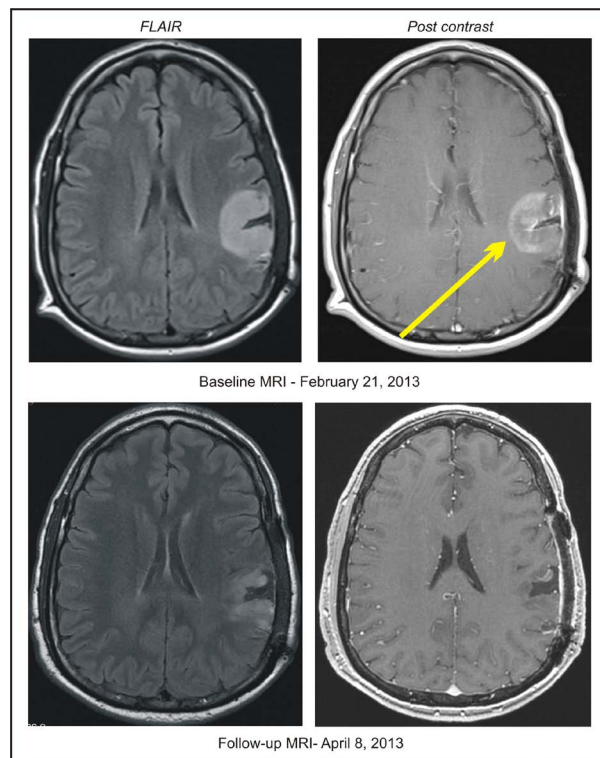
Patient 4, baseline and follow-up MRI of the head indicating complete response.
